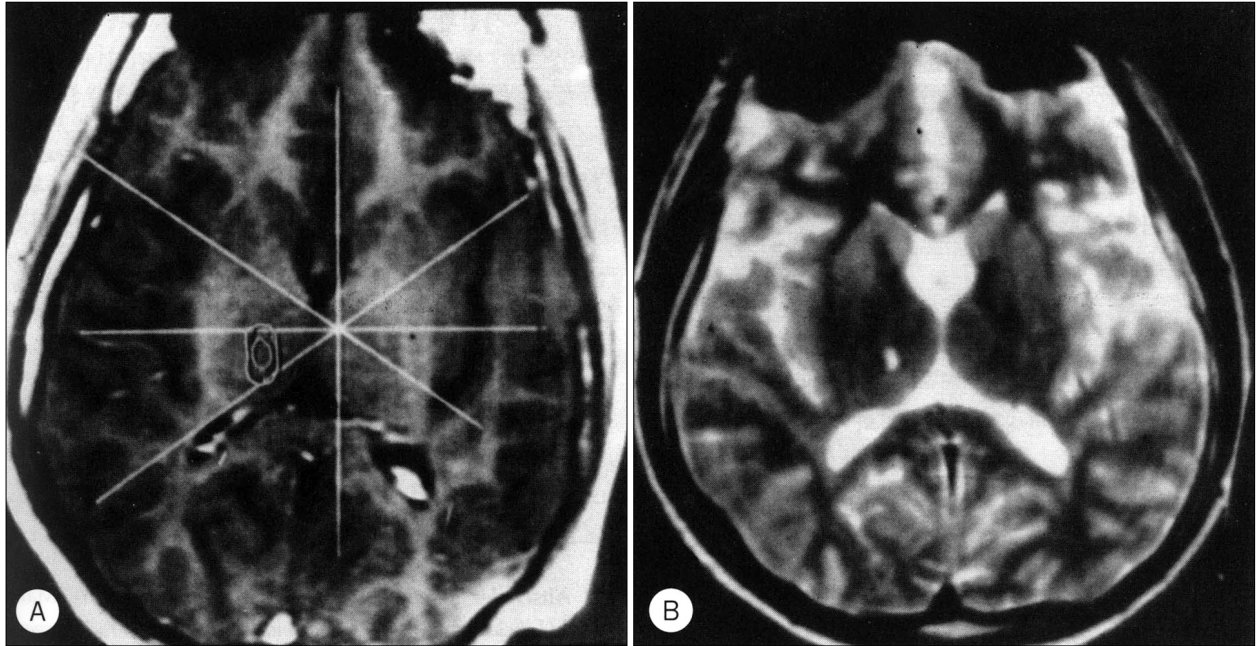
A : MR image demonstrating the planned thalamic target in dystonia. B : Postoperative MR image demonstrating the thalamotomy lesion.
